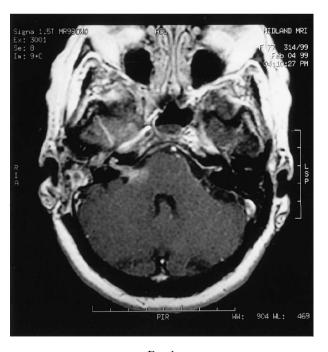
T1-weighted axial MRI demonstrating the lymphoma within the right CPA.
